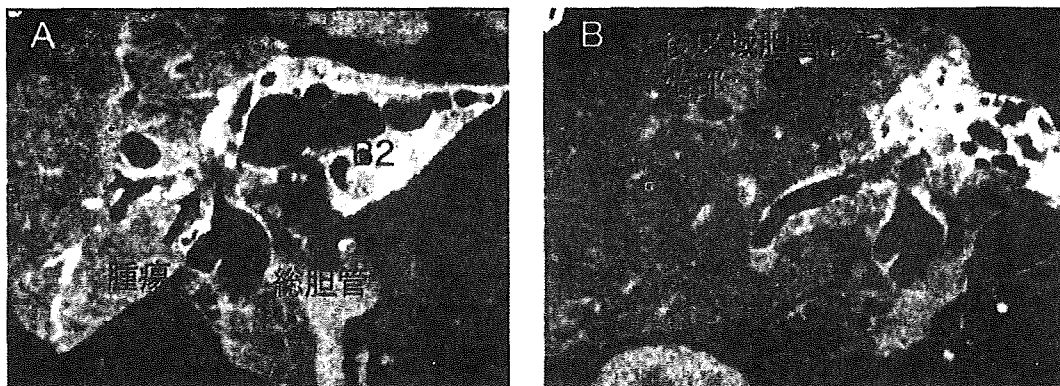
肝門部胆管癌症例のMD-CT (MPR 冠状断像)
